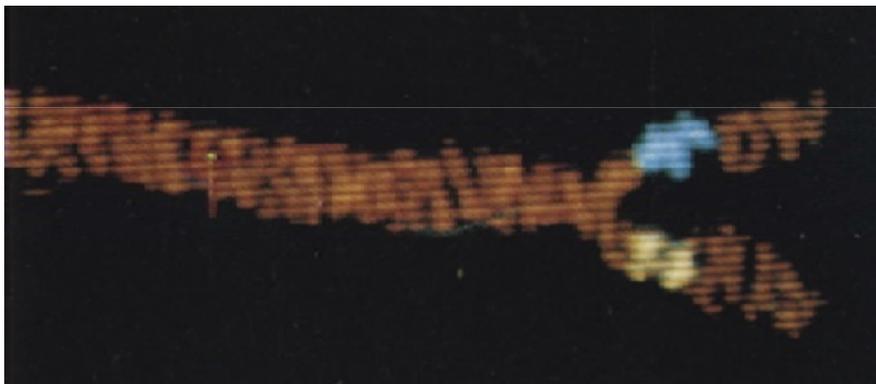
Scan of the carotid artery using the Echoflow system. The display is colour-coded with higher Doppler frequencies from diseased regions shown in yellow and blue. Reproduced from *Ultrasound Med Biol*, Vol. no. 4, Curry GR and White DN, Color coded ultrasonic differential velocity arterial scanner (Echoflow), pp. 27-35, copyright Elsevier (1978).
